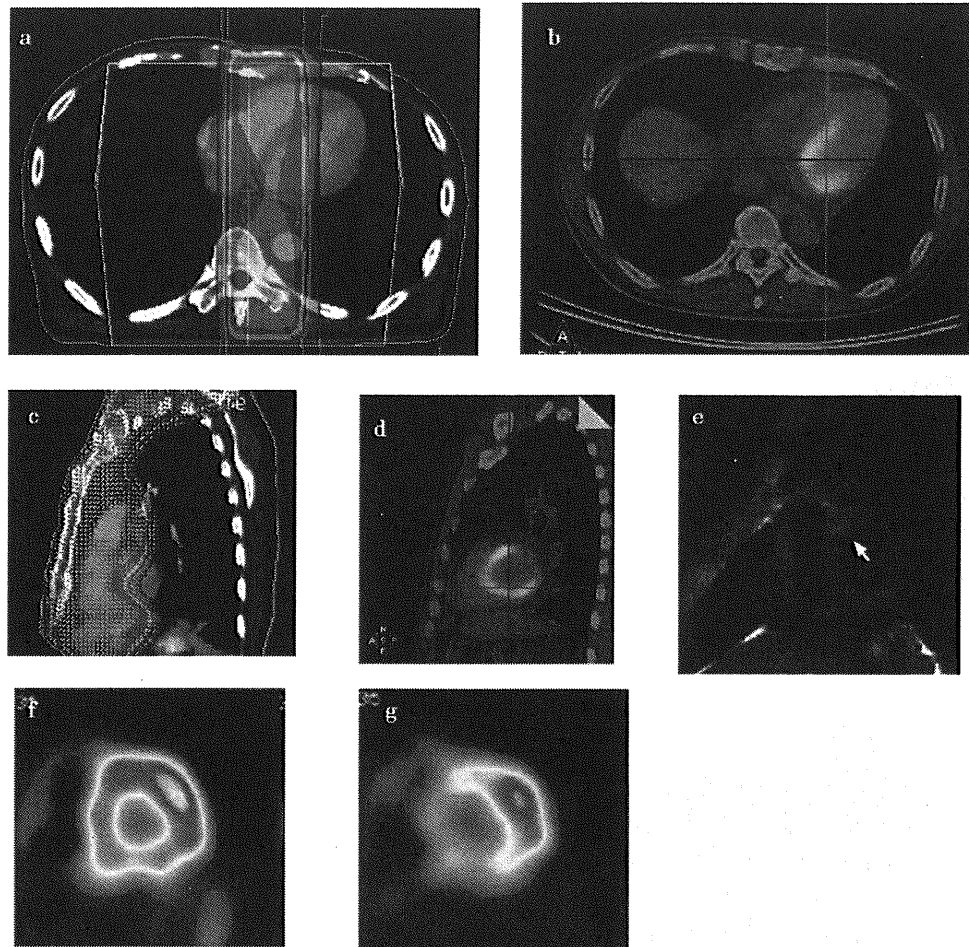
Images of Patient 4 (55-year-old male) at five months after chemoradiotherapy for esophageal cancer (T4N1M1b). (a) Dose-distribution axial image. (b) F-fluorodeoxyglucose-positron emission tomography/computed tomography (FDG-PET/CT) axial image. (c) Dose-distribution short-axis image. (d) FDG-PET short-axis image. (e) Fatsat T2WI magnetic resonance imaging (MRI). (f)  $^{201}\text{TlCl}$  short-axis image. (g)  $^{123}\text{I-BMIPP}$  short-axis image. FDG-PET/CT clearly shows increased FDG uptake in the myocardium corresponding to the irradiated field. Fatsat T2WI MRI shows slight high signal in the base of the septum (arrows) without delayed-enhancement.  $^{123}\text{I-BMIPP}$  uptake is decreased markedly in the lesion, although  $^{201}\text{TlCl}$  uptake is normal.
